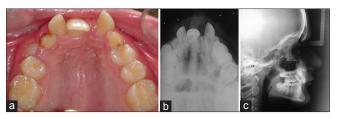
Initial records. (a) Maxillary occlusal photographs, (b) maxillary occlusal radiographs, and (c) cephalometric radiographs
